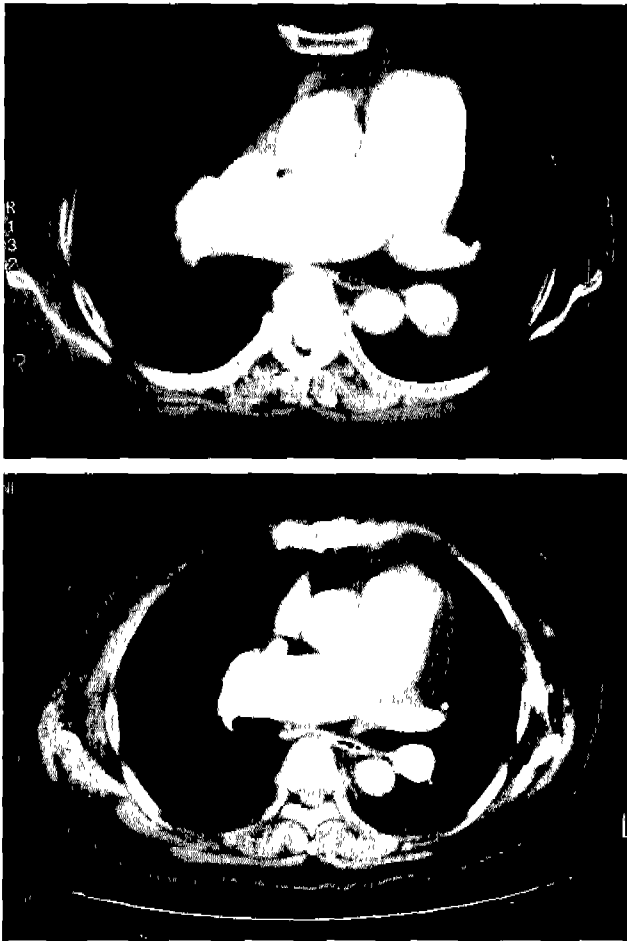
Dynamic chest computed tomography in Patient 5. A. Preoperatively anomalous pulmonary vein is connected to the SVC above the markedly dilated right pulmonary artery. B. Postoperative follow-up at 15 months shows free cavoatrial flow. SVC, superior vena cava
